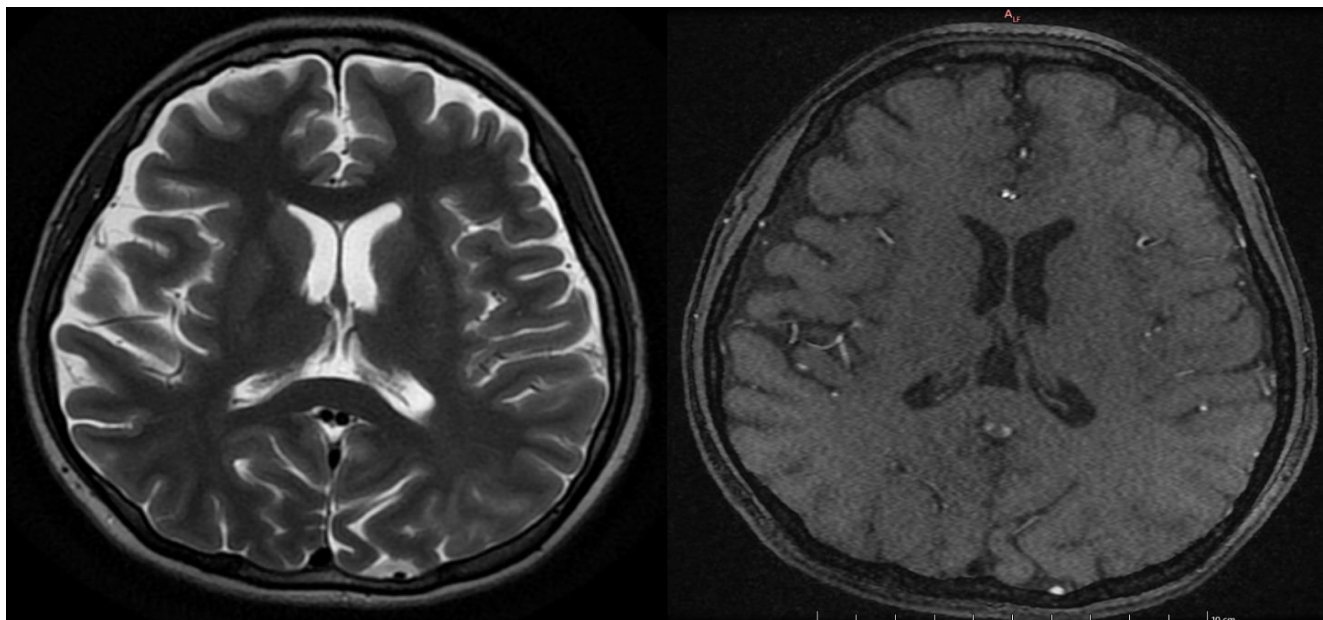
T2 brain MRI without evidence of injury to the parenchyma or meninges.
